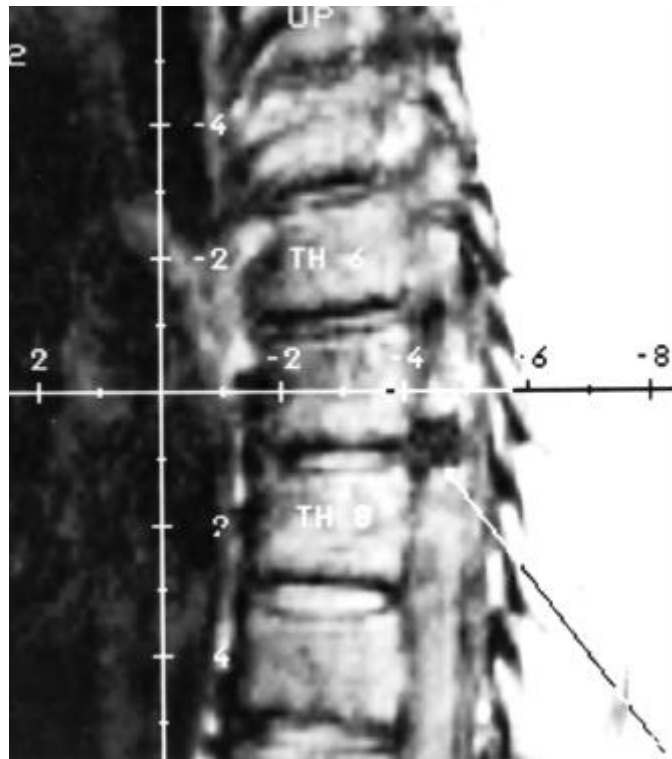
An MRI scanning with sagittal T1 and T2 weighted image with gadolinium contrast showing a large herniated disc at the T7/8 level and a smaller herniated disc at the T6/7 level diagnosis.
